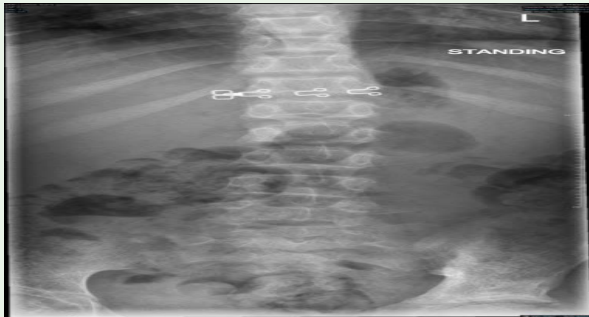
AP Radiograph thoraco-lumbar spine shows mild dextro-scoliosis, secondary to her right hip pathology.
